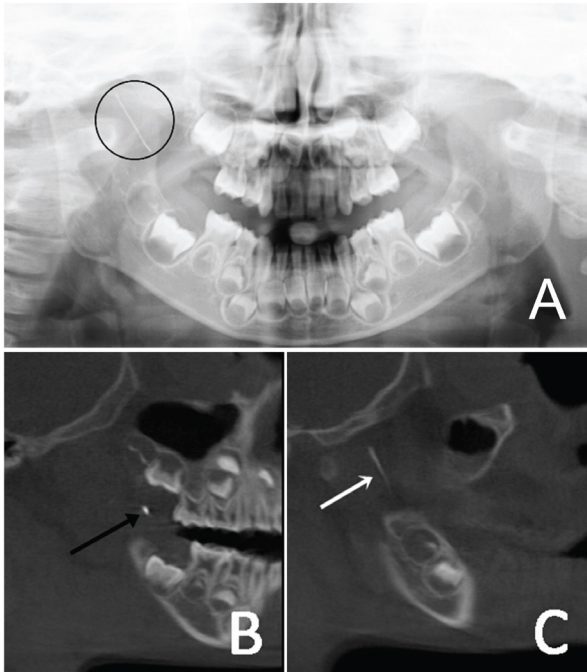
Preoperative radiographic images showing the broken needle and gutta-percha. (A) Broken dental needle in panoramic view, and a computed tomography (CT) sagittal view of the (B) gutta-percha and (C) broken dental needle.
